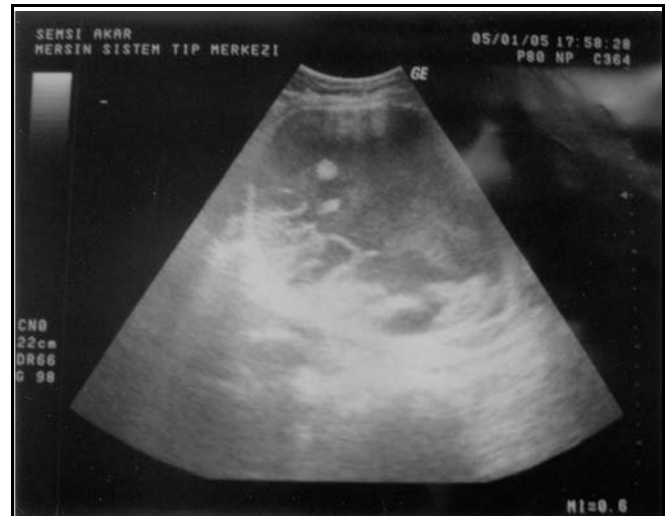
Transvaginal ultrasound image of the endometriosis cyst with papillary projections in the cyst wall.
